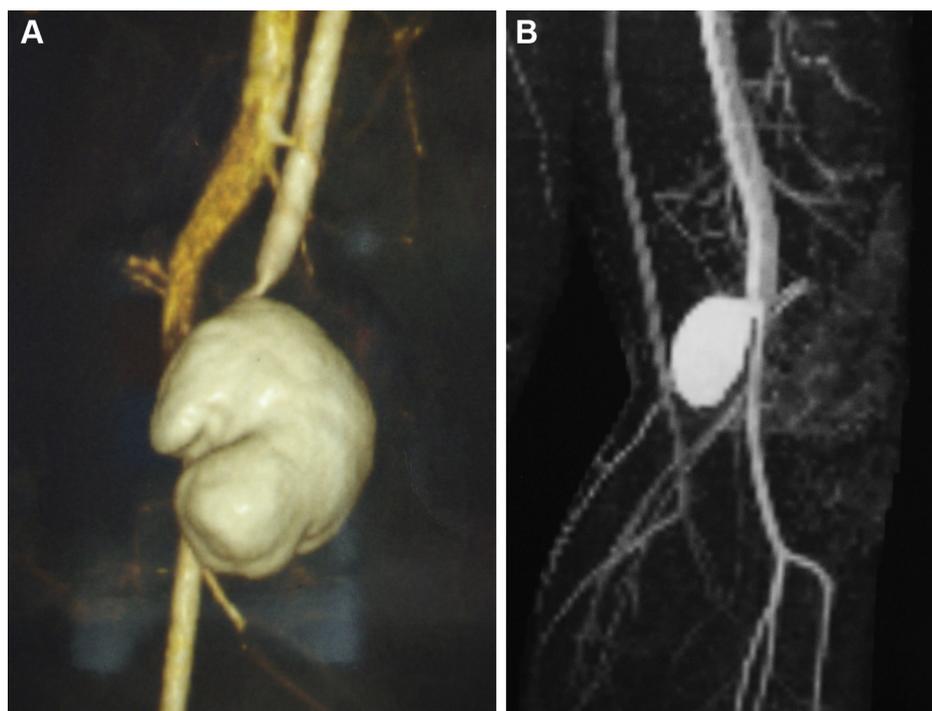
Computed tomography angiogram. (A) Three-dimensional image and (B) two-dimensional image of the pseudoaneurysm of the popliteal artery.
